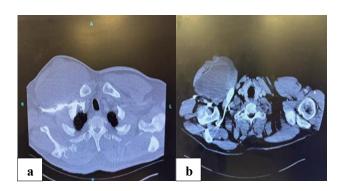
(a) Contrast-enhanced computed tomography reveals right chest wall mass invading the pectoralis muscle and in close proximity to, but not invading, the subclavian vein, and (b) contrast CT revealing large right chest wall sarcoma.
